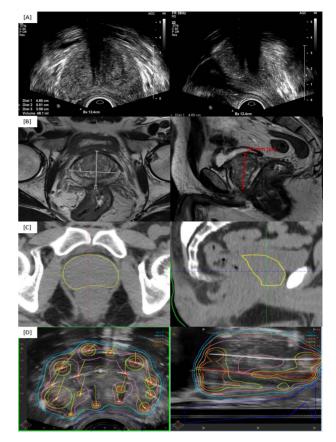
Example of typical volume assessments at the time of (A) trans-rectal ultrasound guided biopsy (width, height and length measurement), (B) MR imaging (width, height and length measurement), (C) CT based volume assessment (yellow contoured volume) and (D) the time of brachytherapy (red volume contour).
